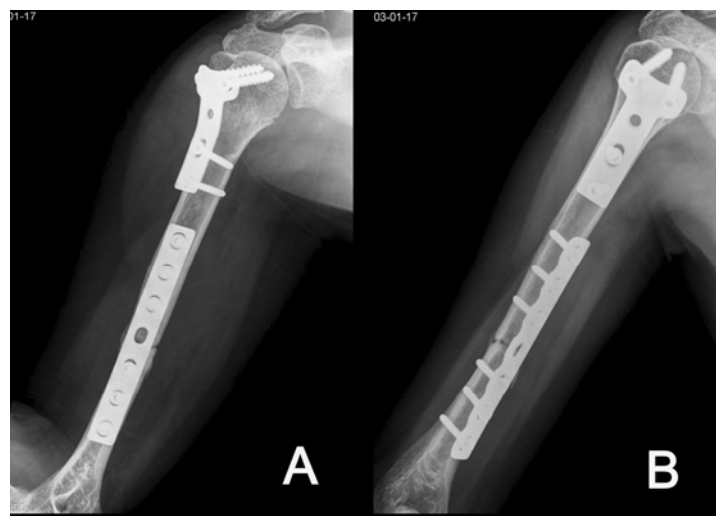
The previously described patient was treated with open reduction and internal fixation with double plates. Nine months after the operation, there was persistent fracture gap which required autogenous bone graft. However, there were no radiographic signs of avascular necrosis in the humeral head.
